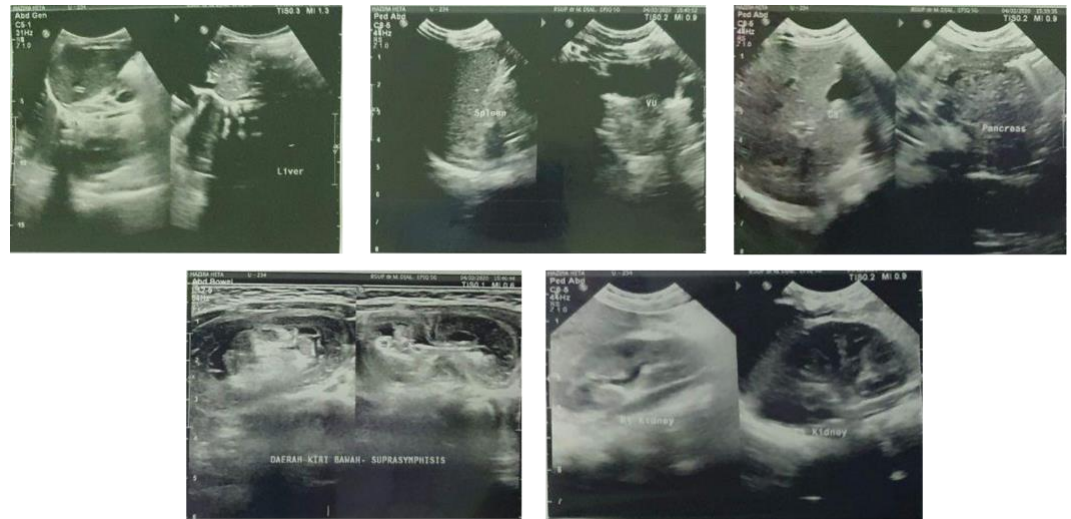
Abdominal ultrasonography results
